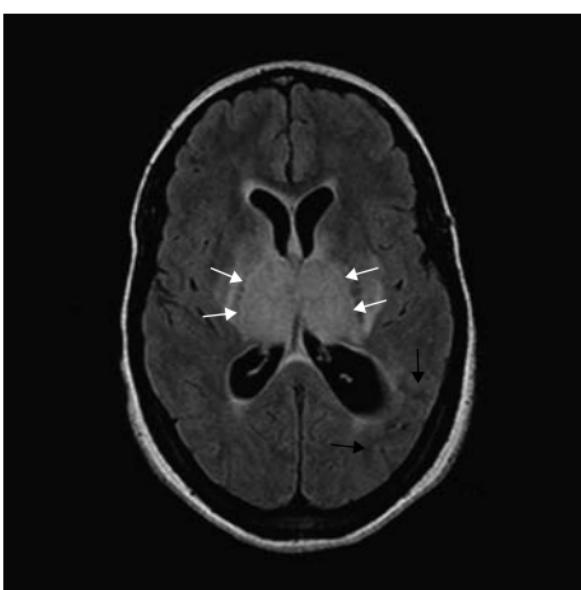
Straight sinus thrombosis: (a) axial T2 and (b) FLAIR. Abnormal hyperintensity within both thalamus and posterior aspects of the lentiform nuclei (white arrows). Note the mature damage in the left inferior parietal lobe due to a previous venous infarct (white arrowheads T2; black arrows FLAIR).
